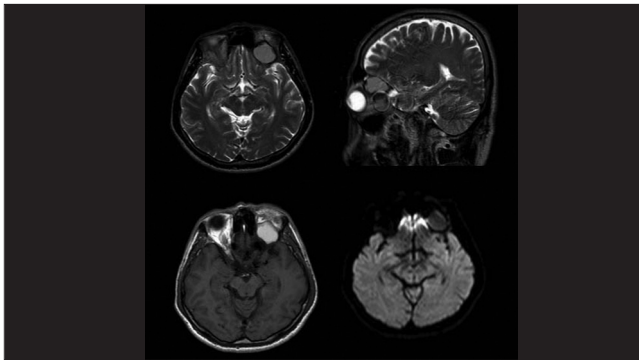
MR imaging of the patient demonstrating retroorbital hematoma
